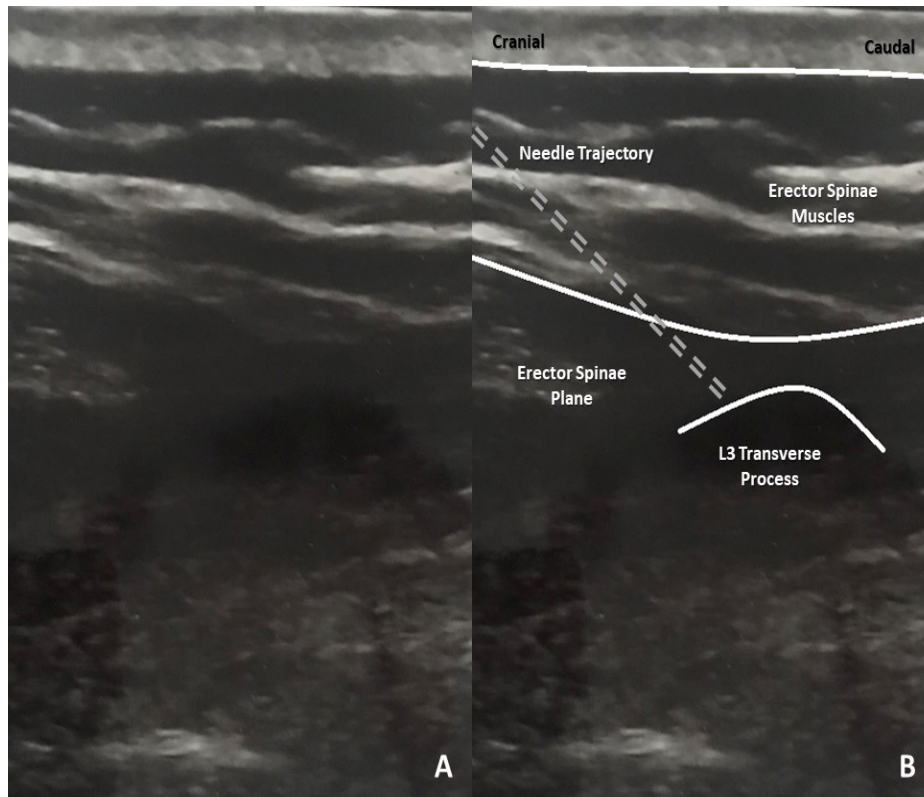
A) These images demonstrate ultrasound (US) imaging using a linear high frequency ultrasound probe of a lumbar ESP block. B) The anatomical structures represented via US imaging are labeled.
